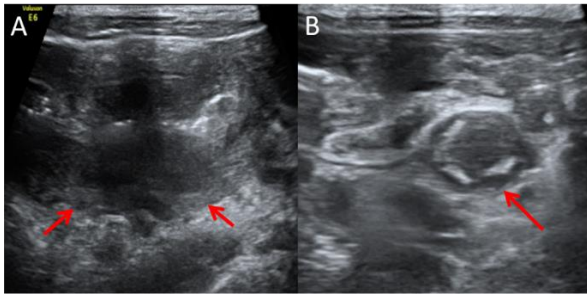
A: longitudinal ultrasound image showing irregular thickening and decrease of echogenicity of the bowel wall. B: cross-sectional abdominal ultrasound showing eccentric thickening of the bowel wall.
